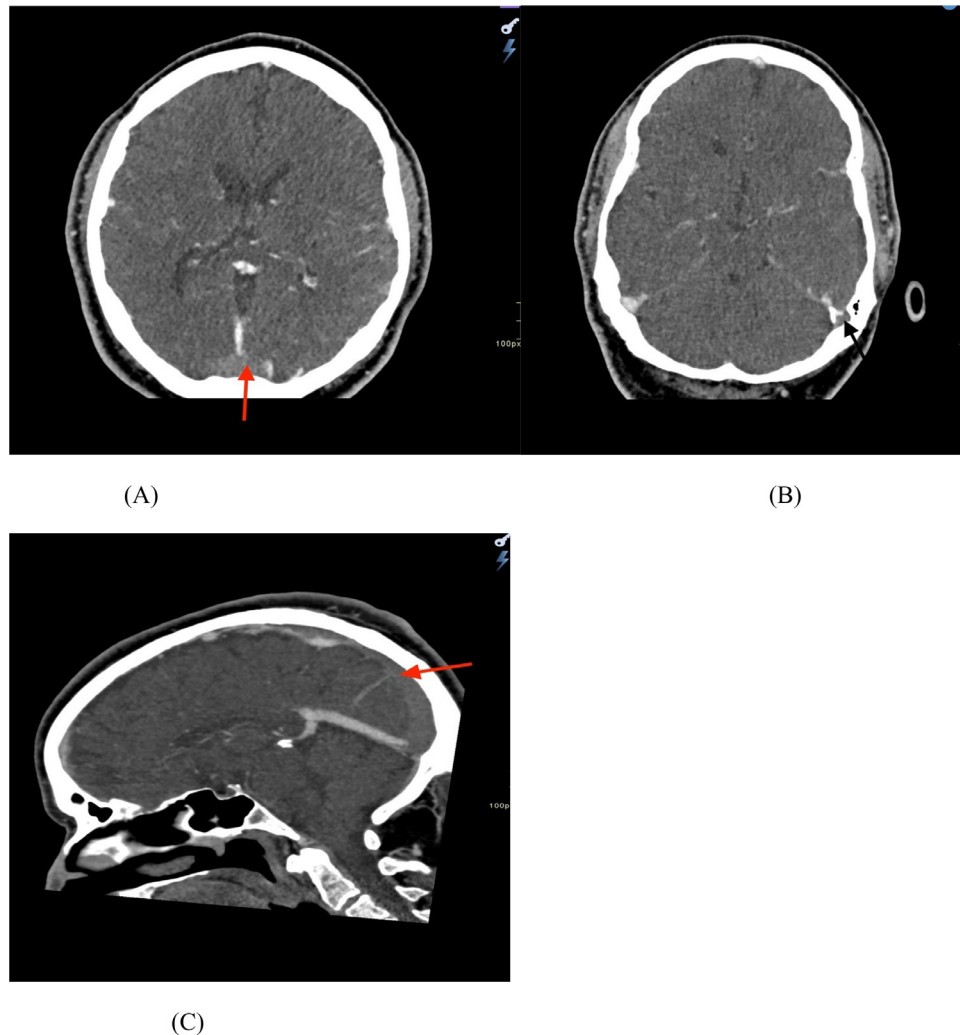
CT venogram of the head (A-C) demonstrated filling defects in the superior sagittal (red arrows) and left transverse sinuses (black arrow) confirming extensive cerebral venous sinus thrombosis (CVST).
